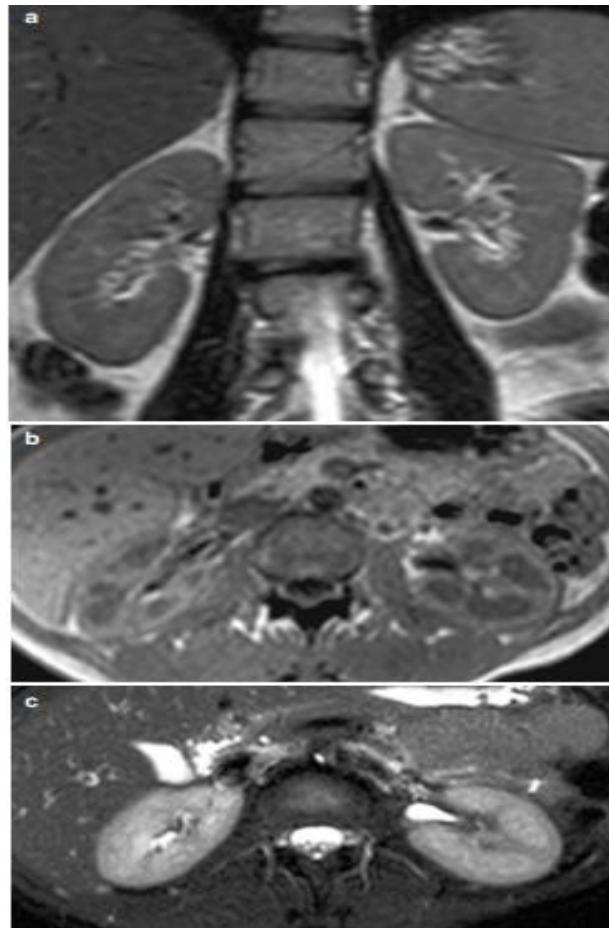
(a–c) Normal kidney on magnetic resonance (MR) imaging. On T1-weighted sequences (a, b) the renal cortex appears much brighter than renal medulla, while on T2-weighted sequences (c) the renal cortex appears slightly less intense than renal medulla
